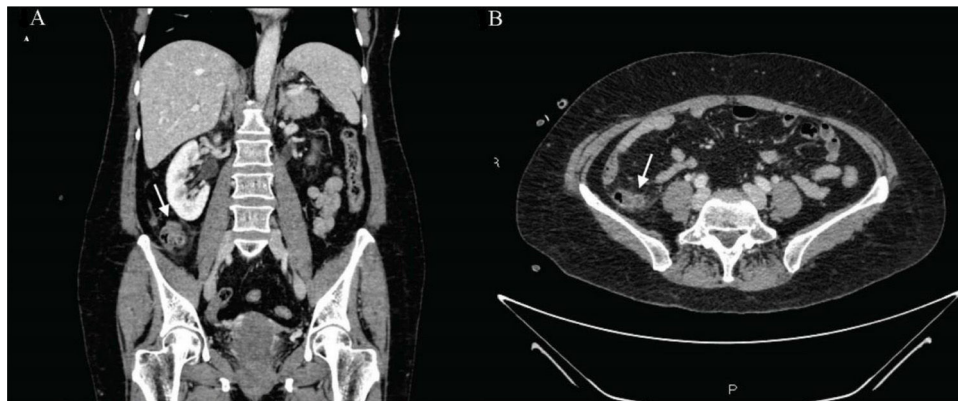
(A) and (B) Coronal and axial views of abdominal CT scans with intravenous contrast medium, showing a diverticular formation of approximately 11 mm in the terminal ileum, with inflammatory changes in the adjacent fat and adjacent layers of free fluid, suggestive of diverticulitis.
